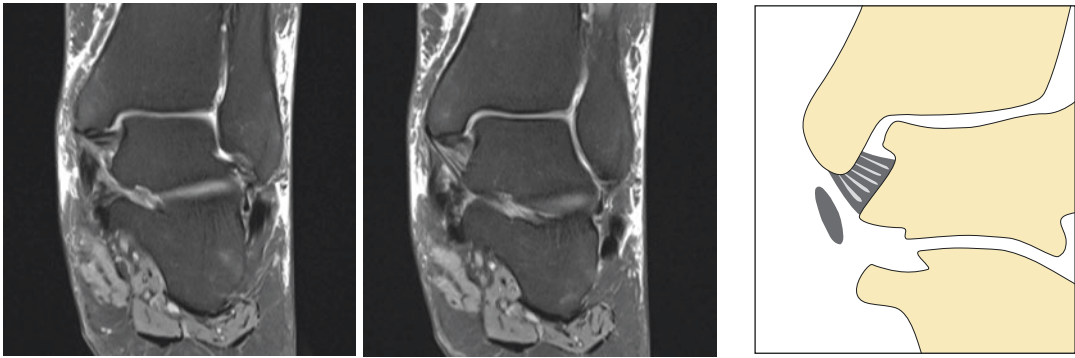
Coronal MR images of the ankle, depicting the deep layers of the tibiotalar ligament (TTL)
